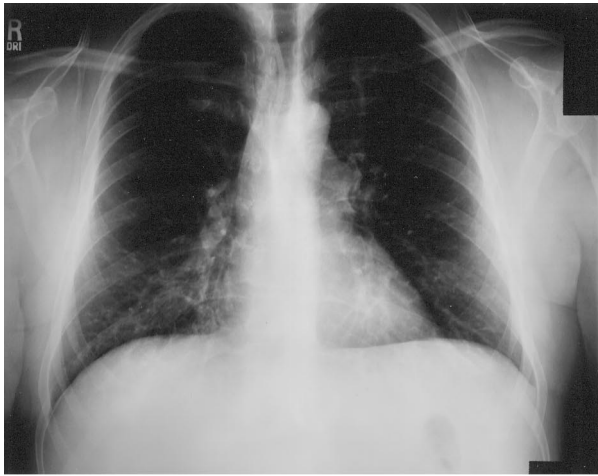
Chest radiograph (*top*) and CT (*bottom*) demonstrating resolution of right middle-lobe and hilar changes following 3 months of antibiotic therapy.
